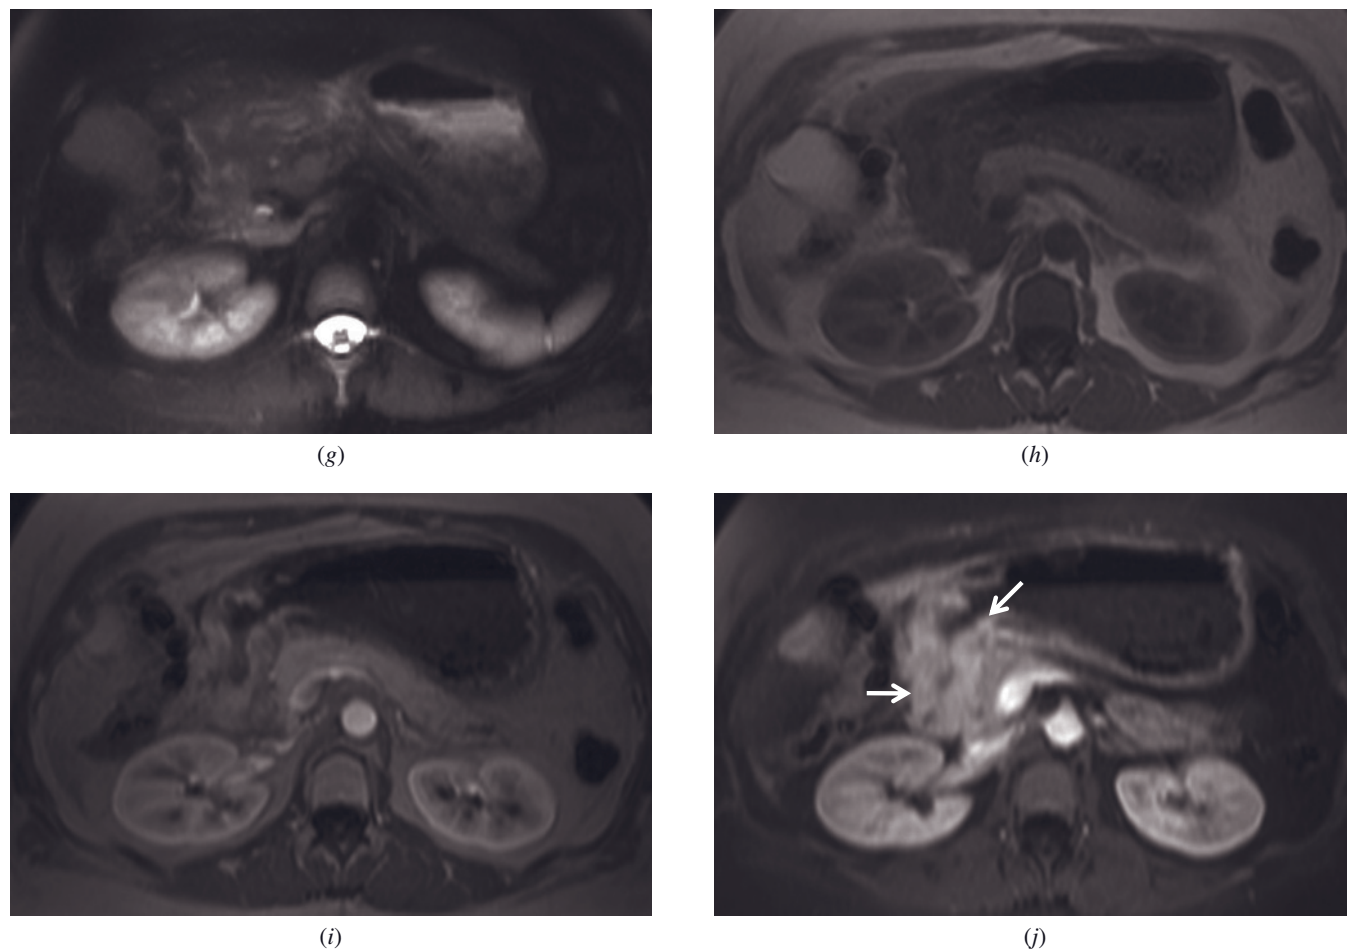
(Continued) T2-weighted single-shot echo-train spin-echo (g), T1-weighted SGE (h), T1-weighted postgadolinium hepatic arterial dominant-phase SGE (i), and T1-weighted postgadolinium hepatic venous phase fat-suppressed 3D-GE (j) images demonstrate gastric adenocarcinoma (arrows, j) in the antrum in another patient. The wall of the antrum is thickened and shows intense enhancement due to tumoral involvement. The tumor extends into the duodenal wall. Note that the stomach is moderately dilated because of outlet obstruction.
